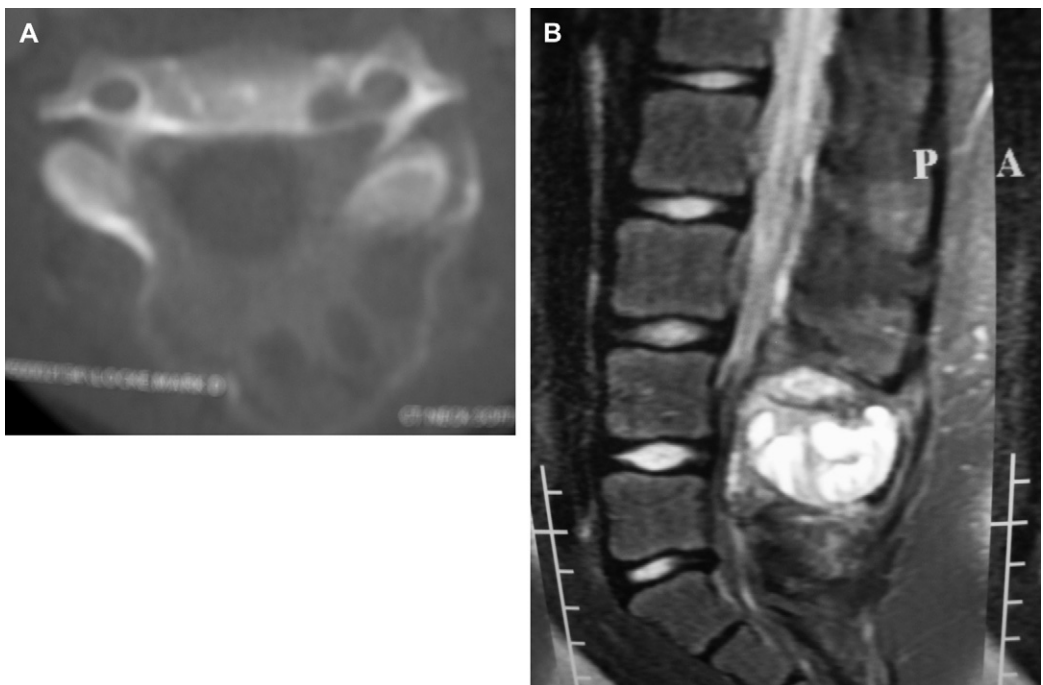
Images of aneurysmal bone cysts (ABC). (A) CT image of cervical ABC showing expansile lesion with characteristic “egg-shell” of remaining cortical bone. (B) Sagittal T2-weighted MRI image of lumbar ABC showing large cystic spaces within lesion.
